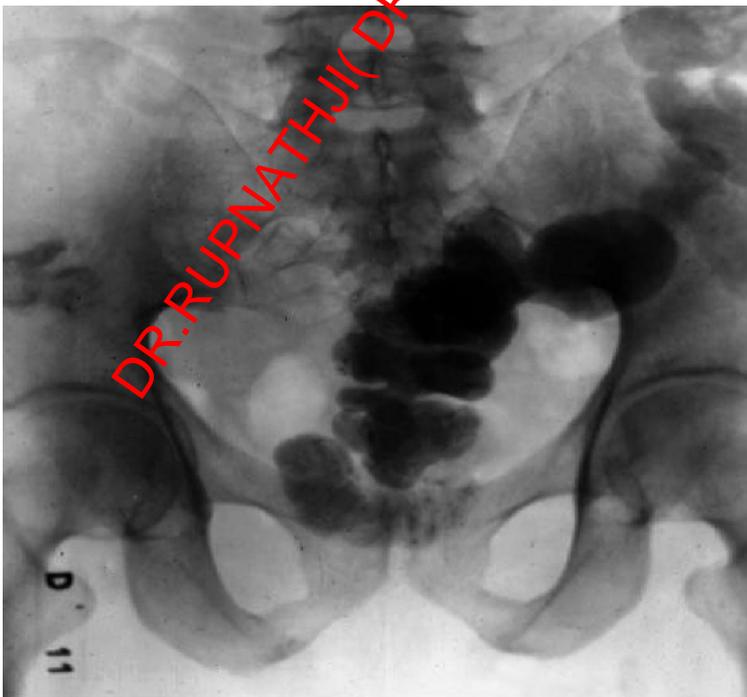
X-ray of a patient operated on of acquired Megacolon by the Duhamel technique. This study was performed 10 years after the surgery.
